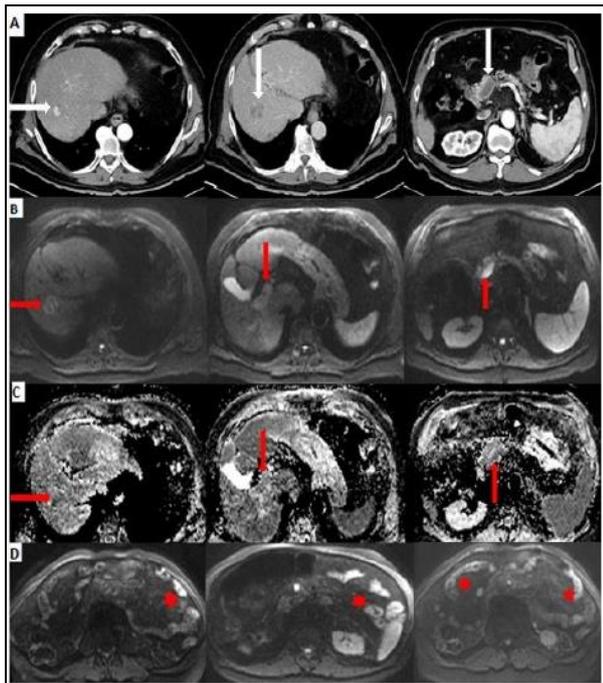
A. 86-year-old man with abdominal discomfort, generalized pain for the past few days. A Dynamic contrast-enhanced axial CT images reveal the hypervascular hepatocellular carcinoma (HCC) [long White arrow], invading portal vein and leading to tumor thrombus of superior mesenteric vein (white arrow). B,C. Diffusion-weighted MRI ($b=1000\text{ s/mm}^2$) and apparent diffusion coefficient maps show the tumor and tumor thrombus with restricted diffusion (red arrow). D. Diffusion-weighted MRI shows ischemic changes of small bowel (star).
